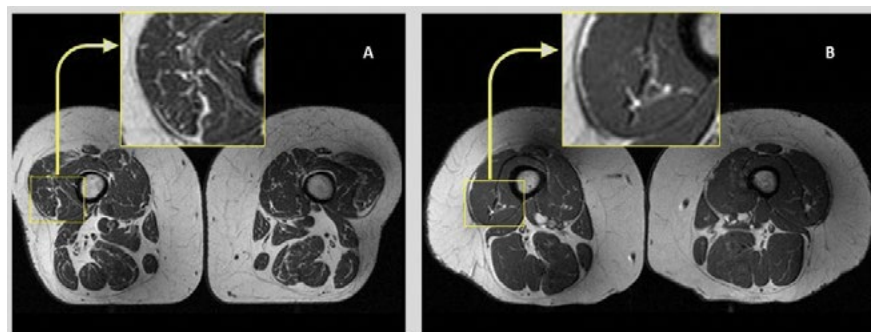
Axial T1-weighted bilateral thigh MR images and magnified frames providing a closer look at the areas in lateral aspects of quadriceps femoris muscles (knee extensors) from two obese, female participants, aged 58 (A) and 62 years (B), respectively. In A, the thigh muscles on both sides demonstrate abundant fatty streaks, consistent with a high Goutallier grade of 45 for this participant, whose diet from the past 12 months consisted 68% of ultra-processed foods. In B, the thigh muscles show fewer fatty streaks as highlighted in the magnified image, consistent with a low Goutallier grade of 17 for this participant, whose diet contained only 36% ultra-processed foods.
